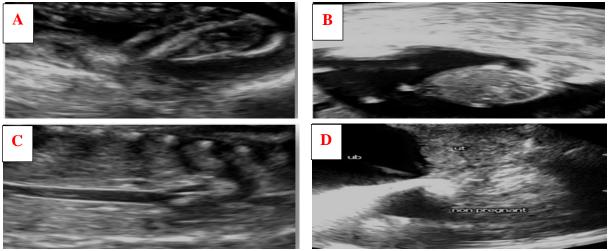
Sonograms showing pregnant uterus, A: clear an echogenic fetal fluid with fetal parts clear (fetal head); B: the fetus appeared from dorsal view and the cephalic diameter is clear; C: the fetus chest is clear with the vertebral column and shadows of the ribs, D: non-pregnant uterus cross section without any contents.
